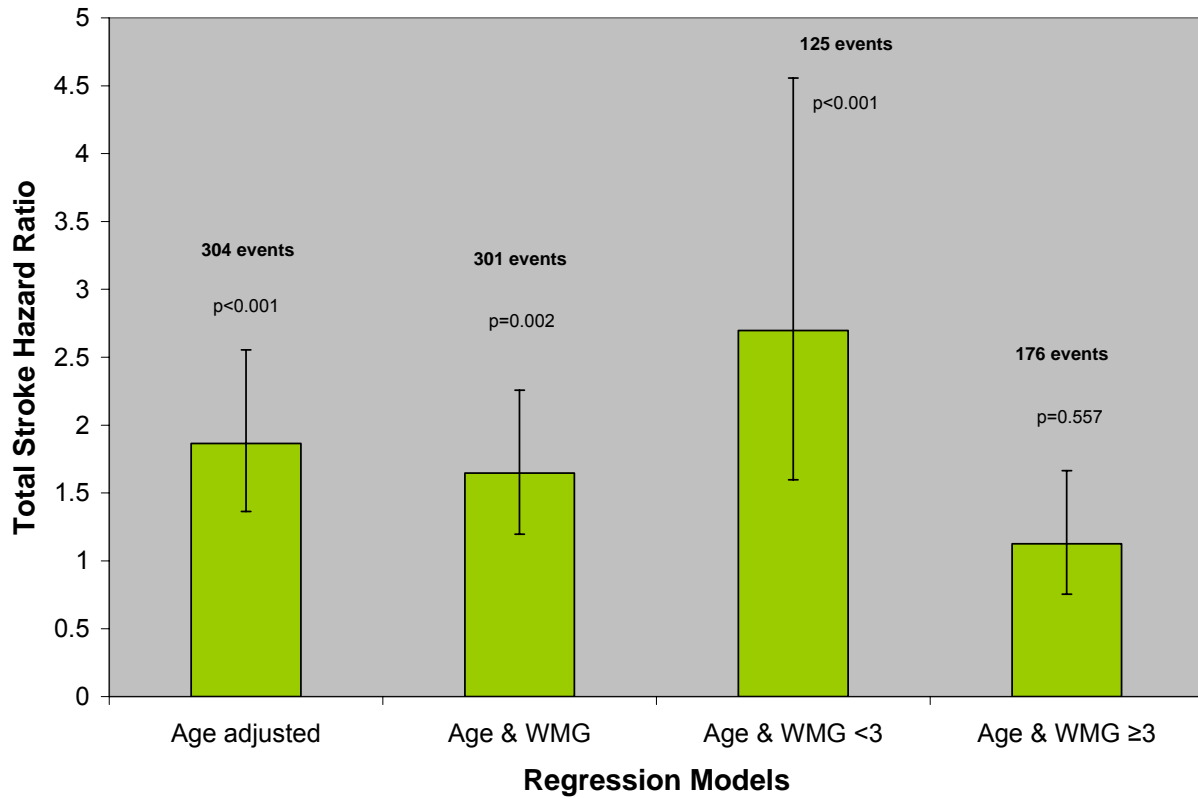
Total stroke hazard ratio at first MRI in the three CHS sites combined compared to Allegheny County
